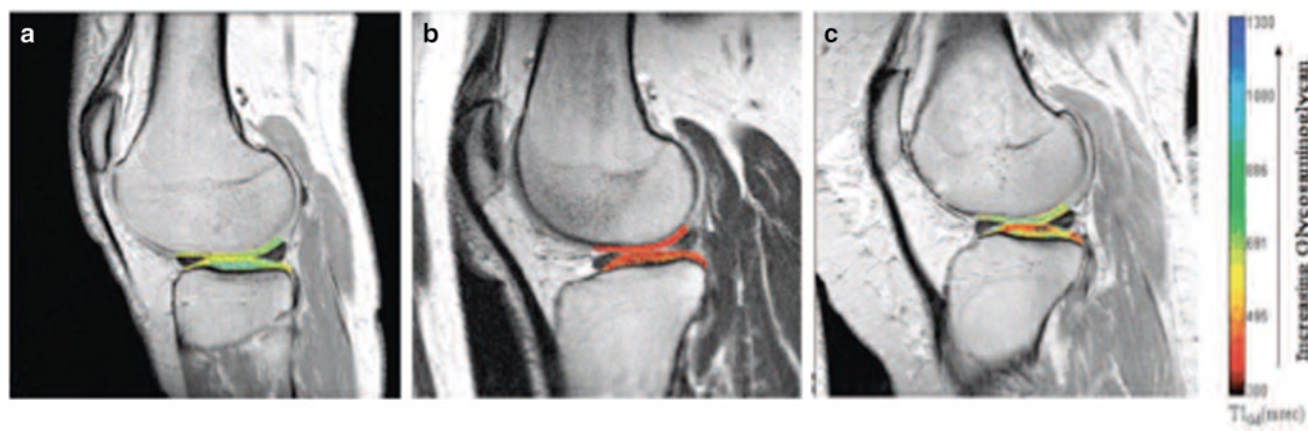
The dGEMRIC index obtained after delayed gadolinium-enhanced MRI of cartilage for obese subjects who have no radiographic evidence of joint space narrowing. Representative examples include knees with (a) high global dGEMRIC index in cartilage; (b) low global dGEMRIC index in cartilage; and (c) focal areas of low
